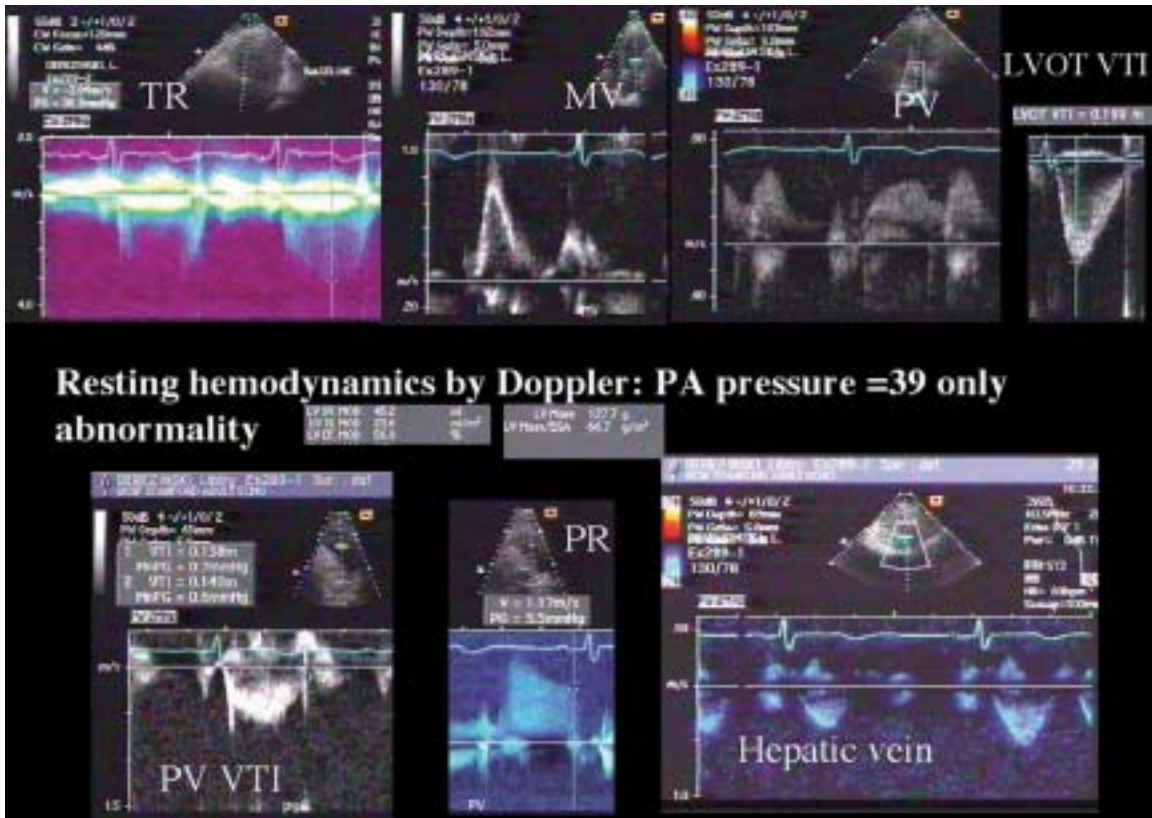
A 44-year-old woman with CREST syndrome reports increasing dyspnea. Her resting echo/Doppler study demonstrates a PASP of 39 mmHg, but was otherwise unremarkable.
